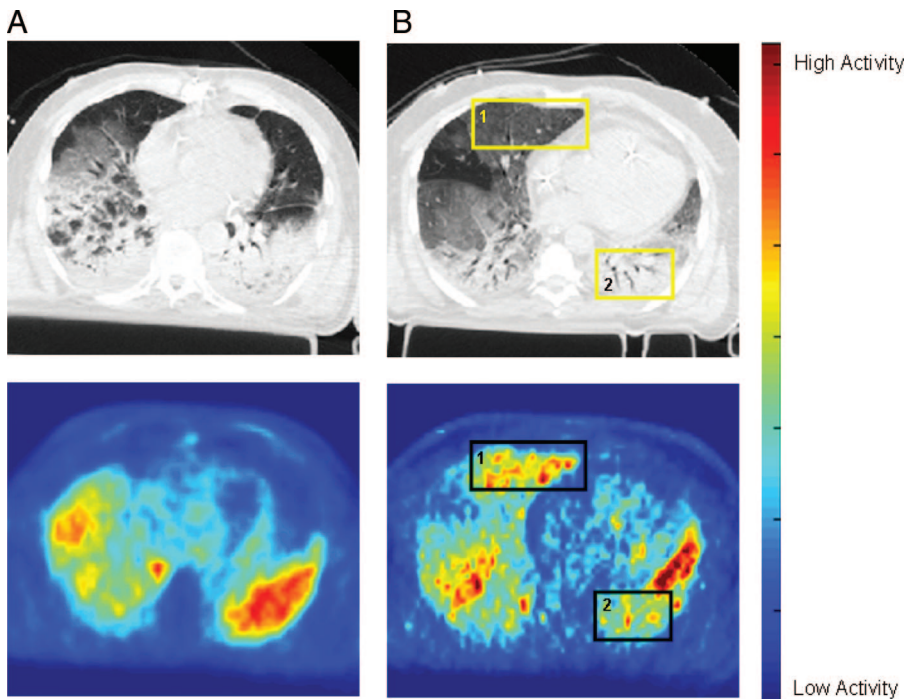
Representative images of cross-registered computed tomography (CT) and [¹⁸F]-fluoro-2-deoxy-D-glucose (¹⁸F)FDG positron emission tomography from two patients with acute lung injury/acute respiratory distress syndrome. The CT image was acquired during a respiratory pause at mean airway pressure. The gray scale is centered at -500 Hounsfield Units with a width of 1250 Hounsfield Units. Positron emission tomographic images represent the average pulmonary ¹⁸F FDG concentration during the last 20 minutes of acquisition (from 37 to 57 minutes since ¹⁸F FDG administration); the color scale represents radioactivity concentration (kBq/mL). A, ¹⁸F FDG distribution parallels that of the opacities detected on CT (patient 7 in Tables). B, Intense ¹⁸F FDG uptake can be observed in normally aerated regions (patient 4 in Tables) (square 1), while activity is lower in the dorsal, "nonaerated" regions of both lungs (square 2; patient 4 in Tables).
